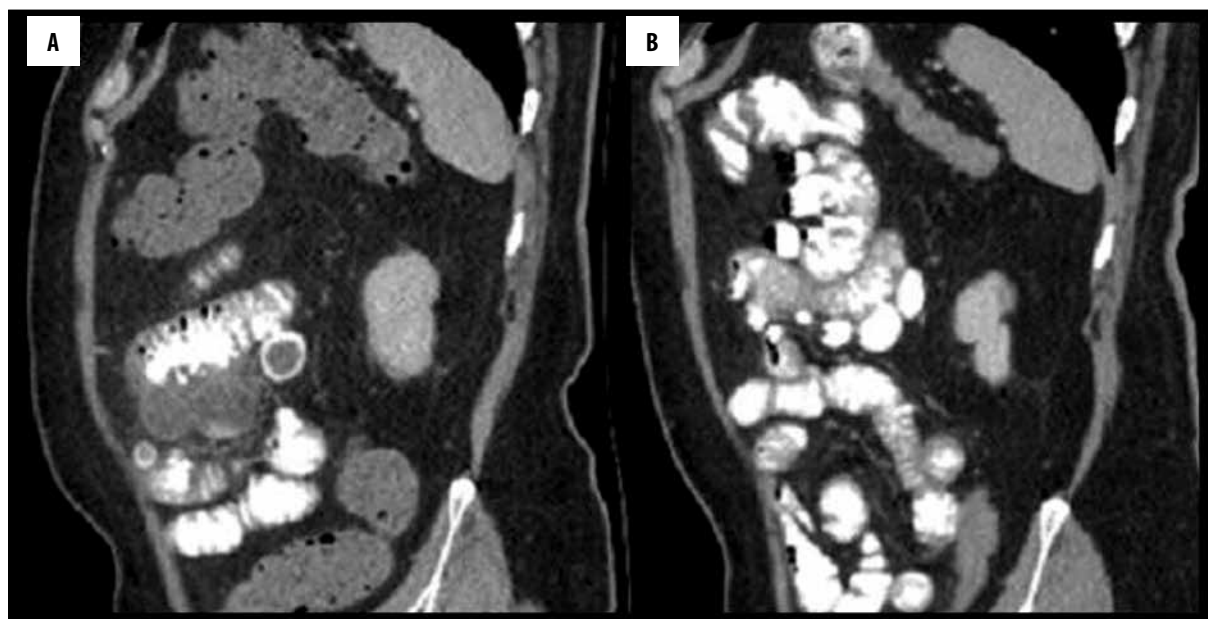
Contrast-enhanced abdominal CT, with oral contrast medium: sagittal reformatted images. Multiple diverticula are observed at the jejunum (A, B); (A) There is a segment of the jejunum with diverticula involved by an inflammatory process; (B) Control CT after medical treatment at the same level of the abdomen showed that diverticulitis findings were regressed.
